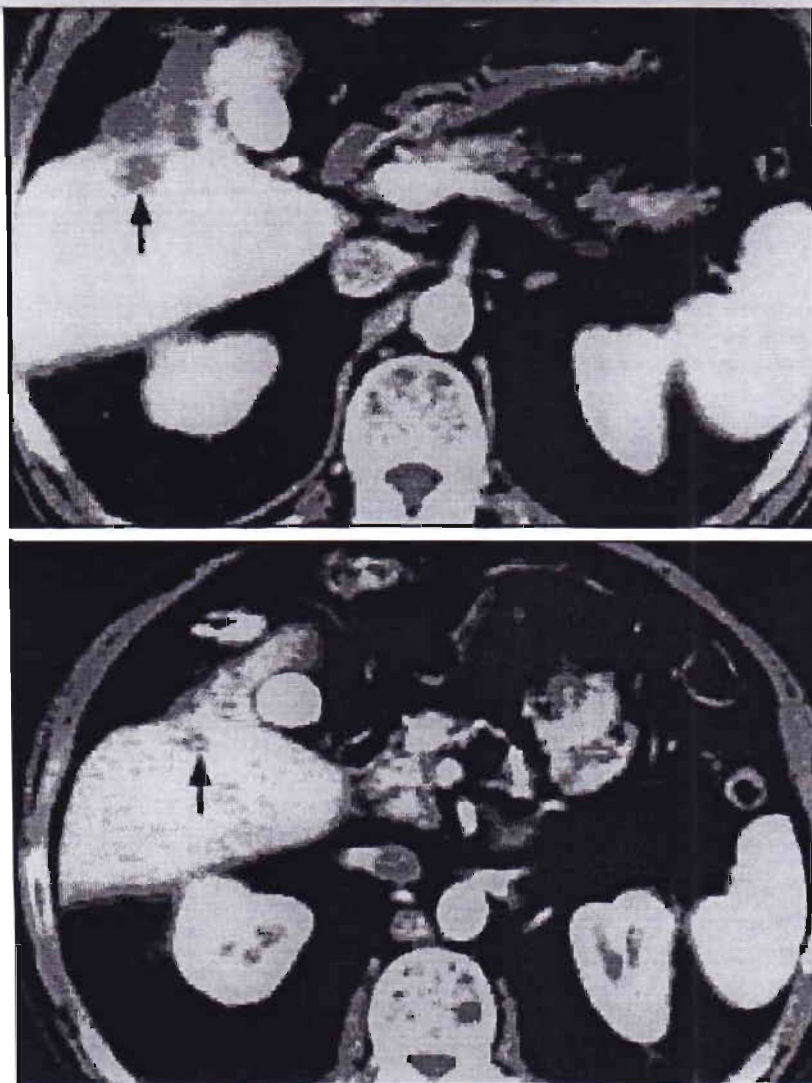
Abdominal computed tomogram showing a hepatic metastasis (arrow) before chemotherapy (top) and 17 weeks after chemotherapy (bottom); the later image shows a substantial reduction in the bulk of the hepatic tumour
